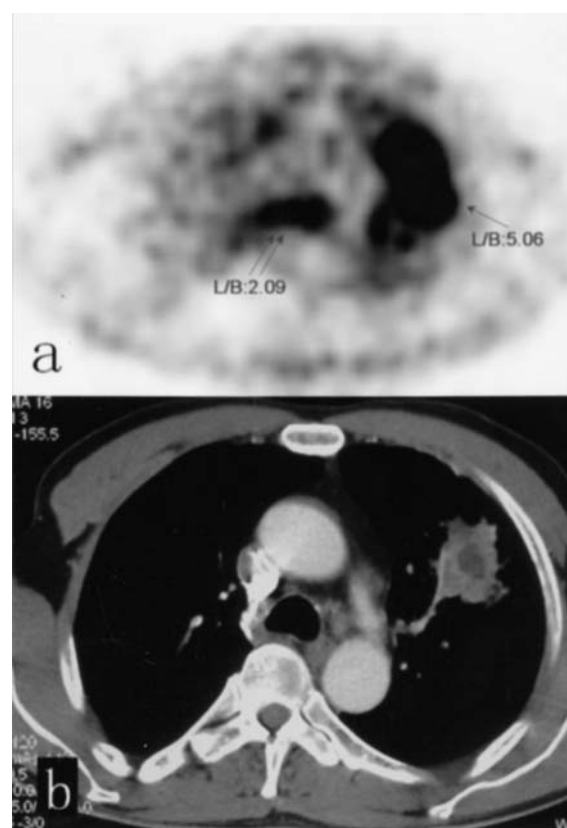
False-positive GCPET in a 56-year-old man with a pulmonary abscess. GCPET (a) shows a high accumulation of FDG in the left upper lobe (arrow, L/B:5.06). The CT (b) shows a large mass in the left upper lobe.
